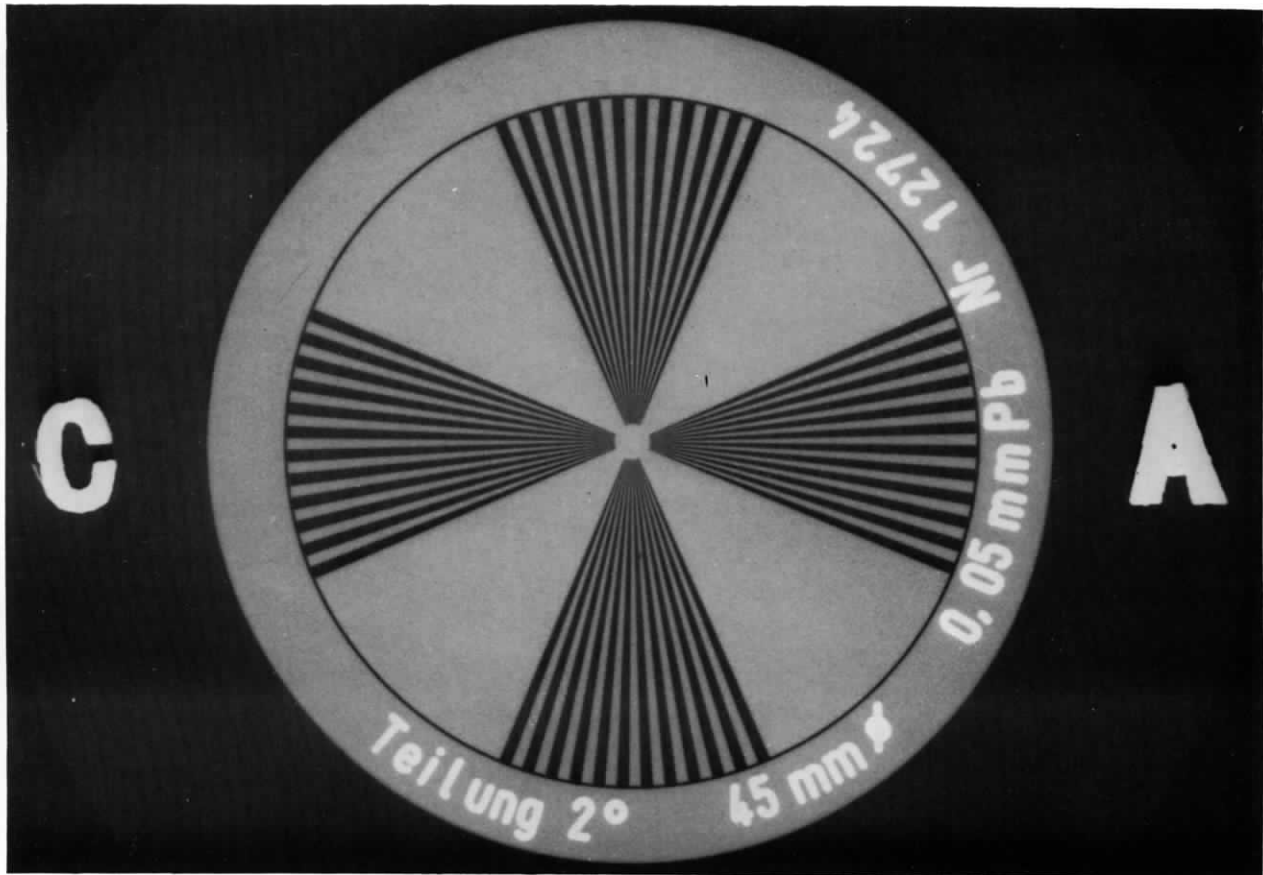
Contact radiograph of star test target made of 0.05-mm thick lead with 2° angles for the bars and spaces.
